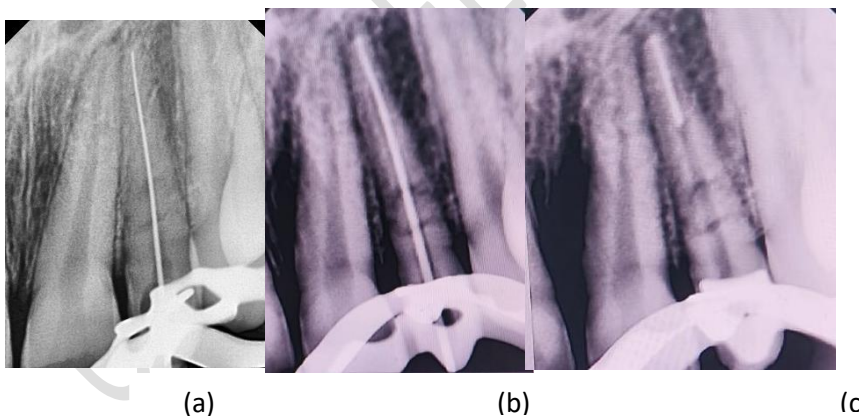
(a) Working length radiograph. (b) Master apical radiograph (c) Post space preparation
